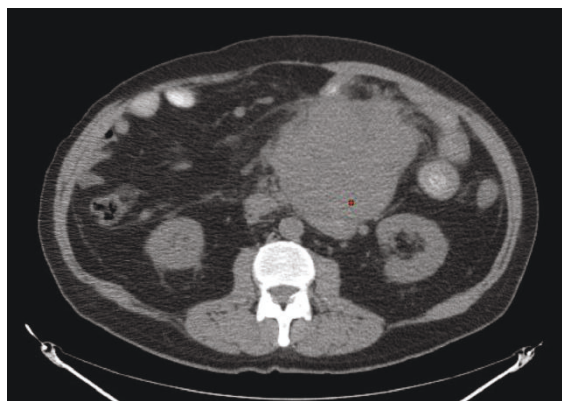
CT scan of the abdomen prior to chemotherapy demonstrating a large mesenteric mass consistent with biopsy proven lymphoma.
